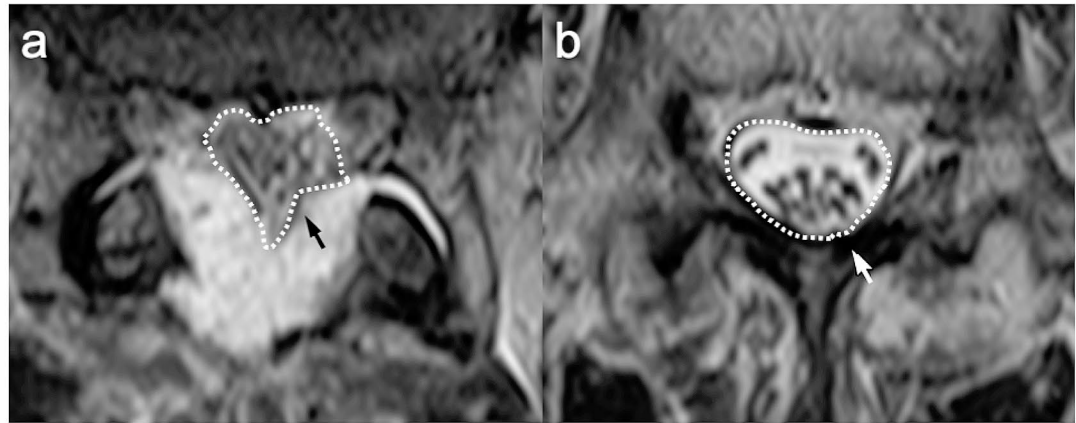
Measuring minimal dural sac index (MDSI) for indirect assessment of postoperative epidural hematoma (EDH) volume. On the postoperative axial MRI T2 weighted image, the minimal cross-sectional area of the dural sac at the surgical level (a; dot circle with black
